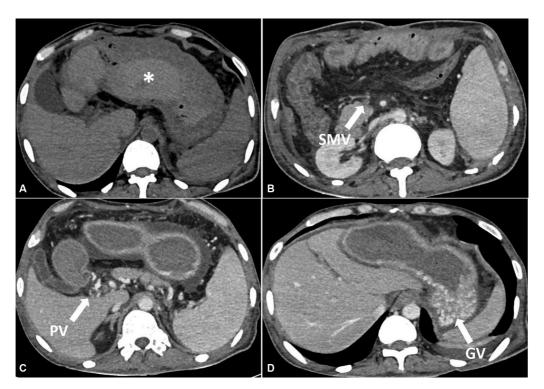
Noncontrast computed tomography (CT) axial image (A) showing a distended stomach with hyperdense blood (asterisk) within it. Contrast-enhanced CT axial images (B–D) showing thrombosed portal vein (PV), superior mesenteric vein (SMV) with gastric varices (GV) along the fundus of the stomach.
